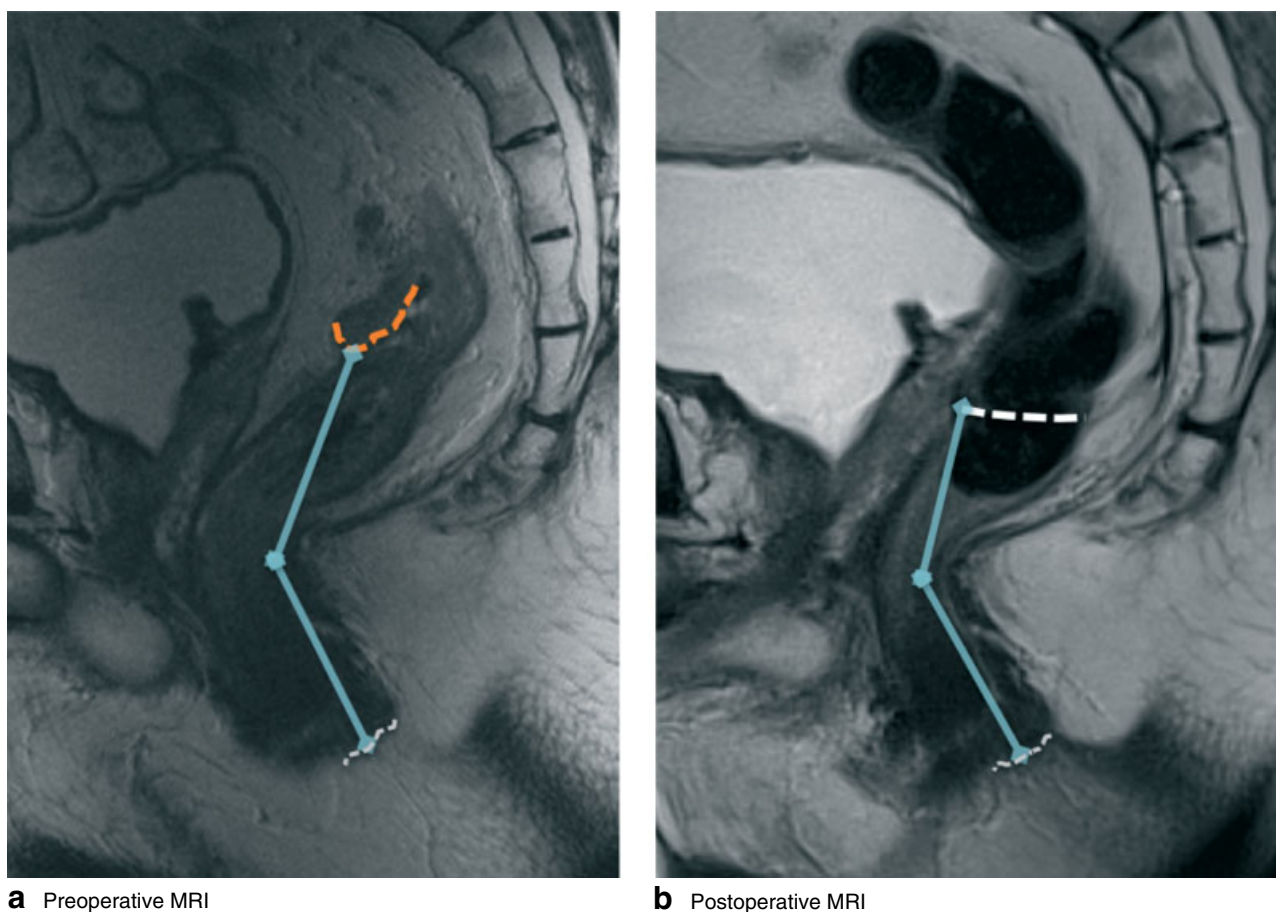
Distal resection margin after partial mesorectal excision. a Preoperative sagittal T2-weighted magnetic resonance imaging (MRI) shows tumour located 9.8 cm from the anal verge. The orange line marks the distal border of the tumour. Rigid proctoscopy located the tumour 11 cm from the anal verge. b Postoperative MRI. Anastomosis located 8.5 cm from the anal verge. The white line marks the level of the anastomosis. For both images the grey line marks the level of the anal verge, and blue lines indicate the distance to the lower border of the primary tumour (a) and the level of the anastomosis (b)
